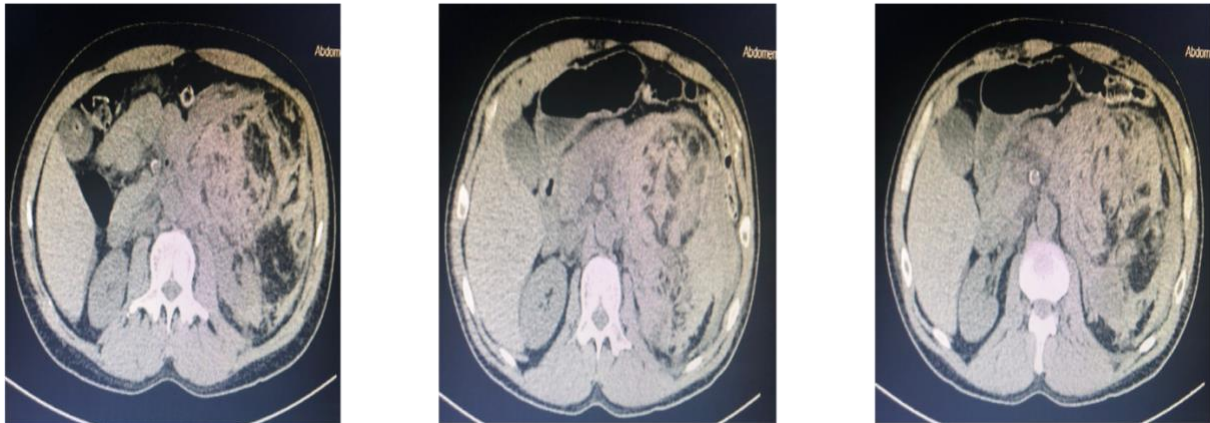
CT scan of the Abdomen and Pelvis without contrast showing left renal exophytic fat containing lesion with adjunct hyper density representing ruptured Angiomyolipoma with adjunct hematoma.
